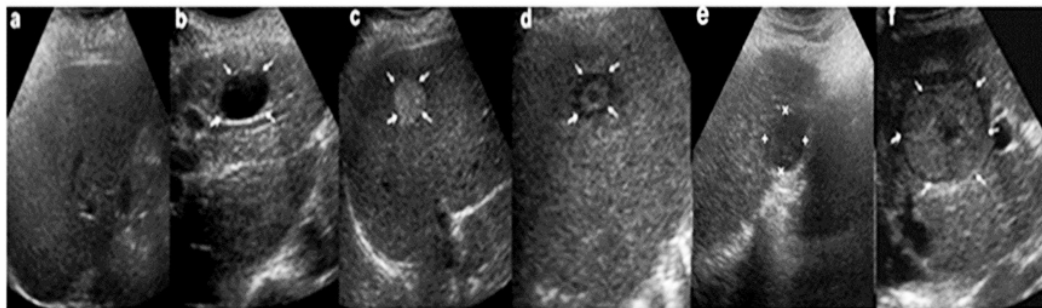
B-Mode ultrasound liver images with appearance of a. Normal liver (homogeneous echotexture with medium echogenicity) b. Typical cyst (thin walled anechoic lesion with posterior acoustic enhancement) c. Typical HEM (well circumscribed uniformly hyperechoic appearance) d. Typical MET ('target' or 'bull's-eye' appearance, i.e. hypoechoic center surrounded by a hyperechoic rim) e. Hypoechoic SHCC f. Heterogeneous echotexture represents complex and chaotic structure exhibited by LHCC due to coexistence of areas of necrosis, fibrosis and active growth areas.
